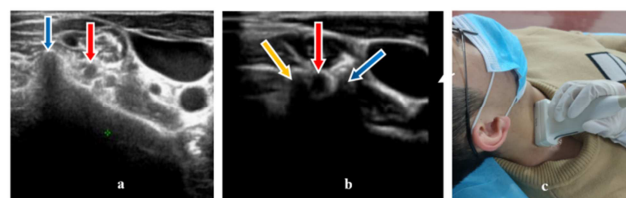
The ultrasonographic characteristics of nerve in short axial section.
